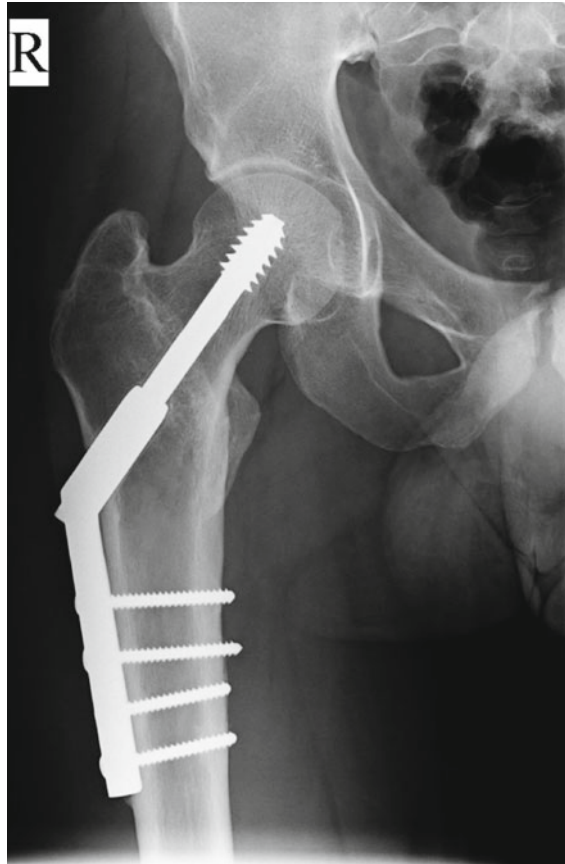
Radiographs show an extracapsular (intertrochanteric) fracture of the right hip, which has been treated by a sliding dynamic compression hip screw and plate (Courtesy of Dilip Malhotra, Bahrain. Reproduced with kind permission of Springer Verlag)
